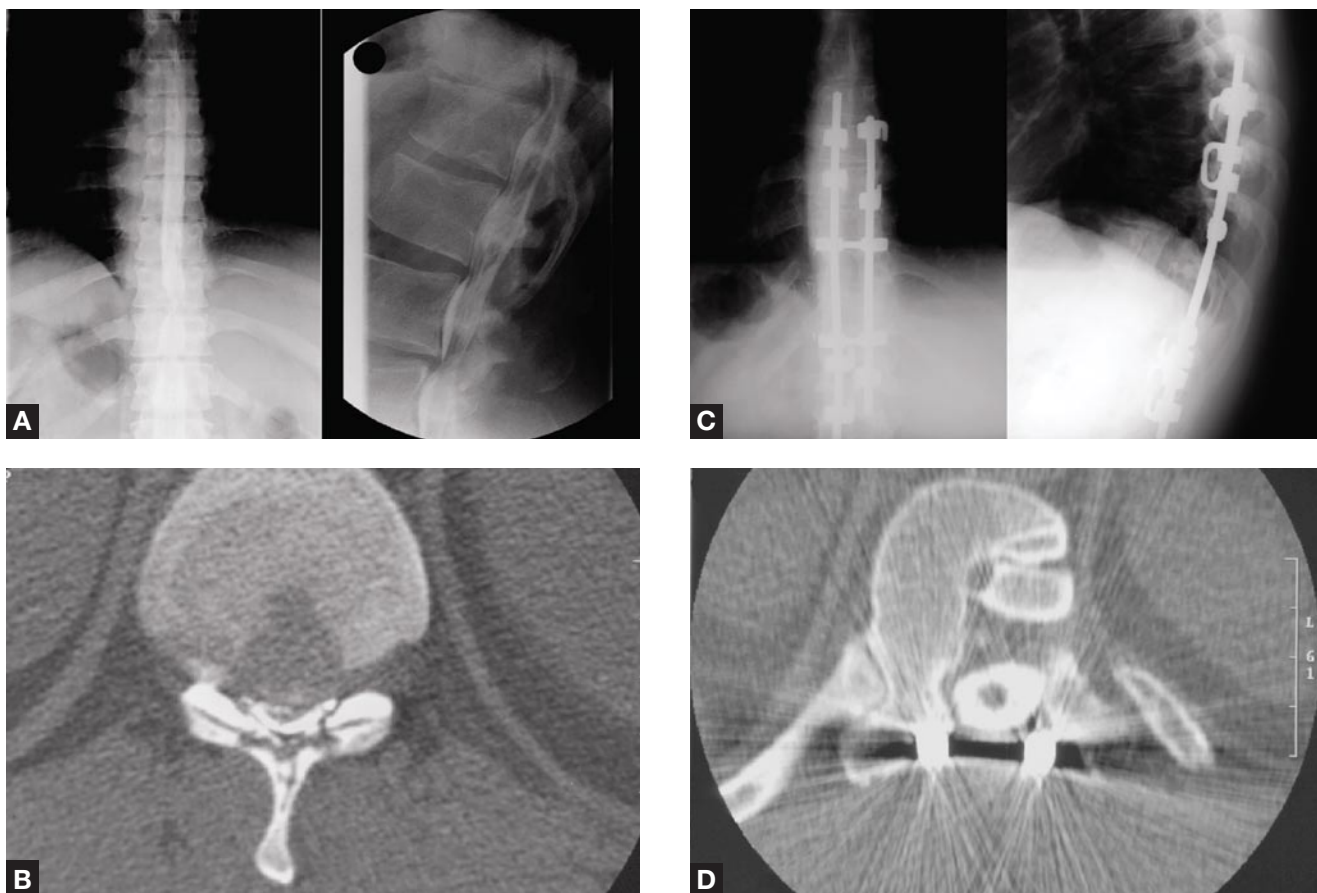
(A) Anteroposterior and lateral myelograms show spondylitic changes and segmental kyphosis with stenosis at T11–T12. (B) Axial computed tomography scan shows severe spinal stenosis at T11–T12. (C) Anteroposterior and lateral radiographs after posterior decompression and instrumented fusion. (D) Axial computed tomography scan shows anterior decompression and restoration of anterior and posterior canal diameter.
